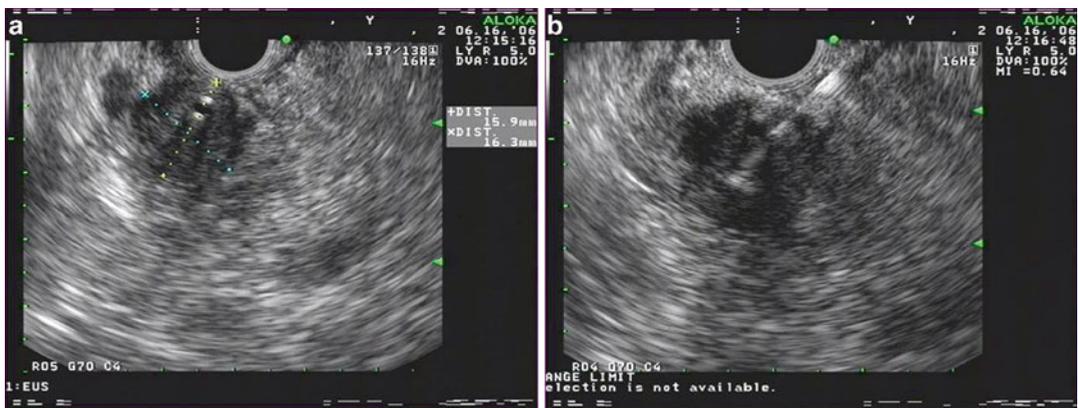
(a) Linear EUS image of an approximately 1.6 × 1.6 cm mass in the pancreatic head with a biliary stent. This lesion was not detected by CT (b) FNA of pancreatic head mass, positive for adenocarcinoma
